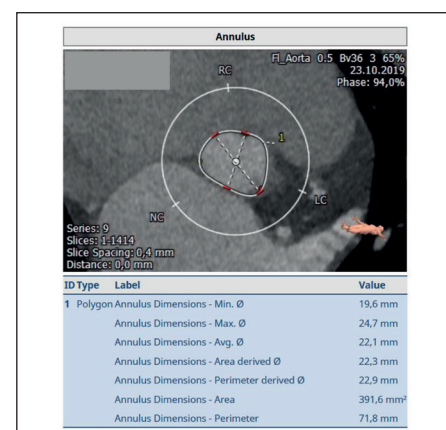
Aortic valve annulus calculations by TAVI-CT.
